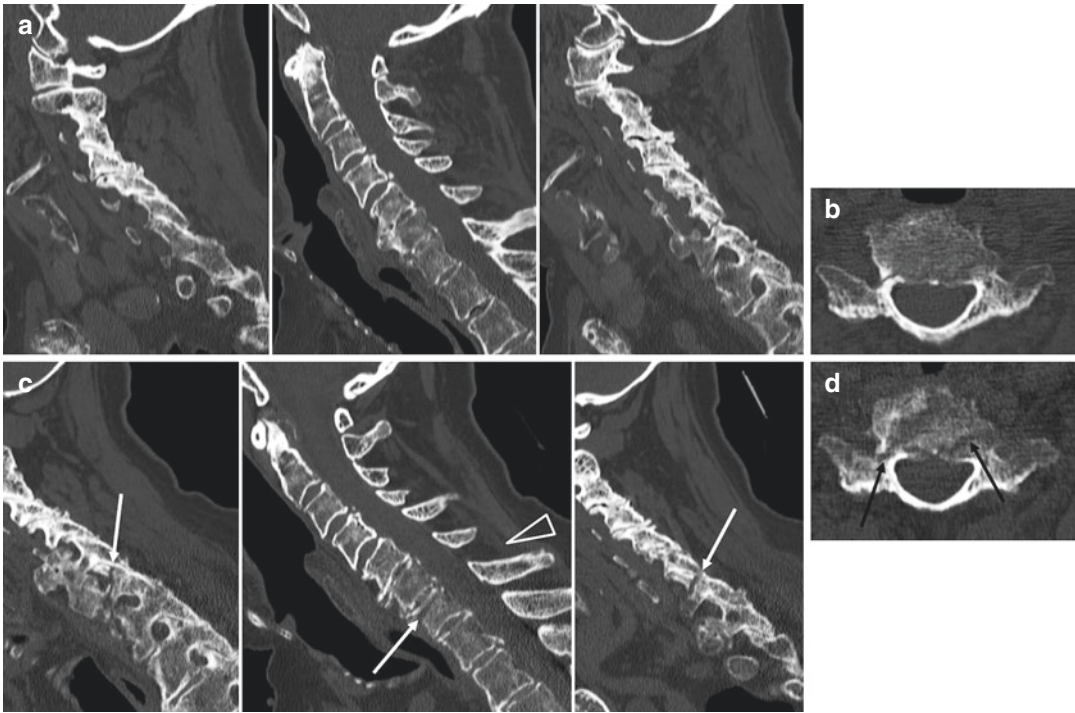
C7 fracture: nonconsecutive right to left 2D-reformatted sagittal (a) and source axial (b) CT images at admission show thin fracture lines in both the posterior hemiarches and in the posterior third of the vertebral body; C6-C7 interspinous space is not clearly enlarged. Despite appropriate immobilization, 10 days
